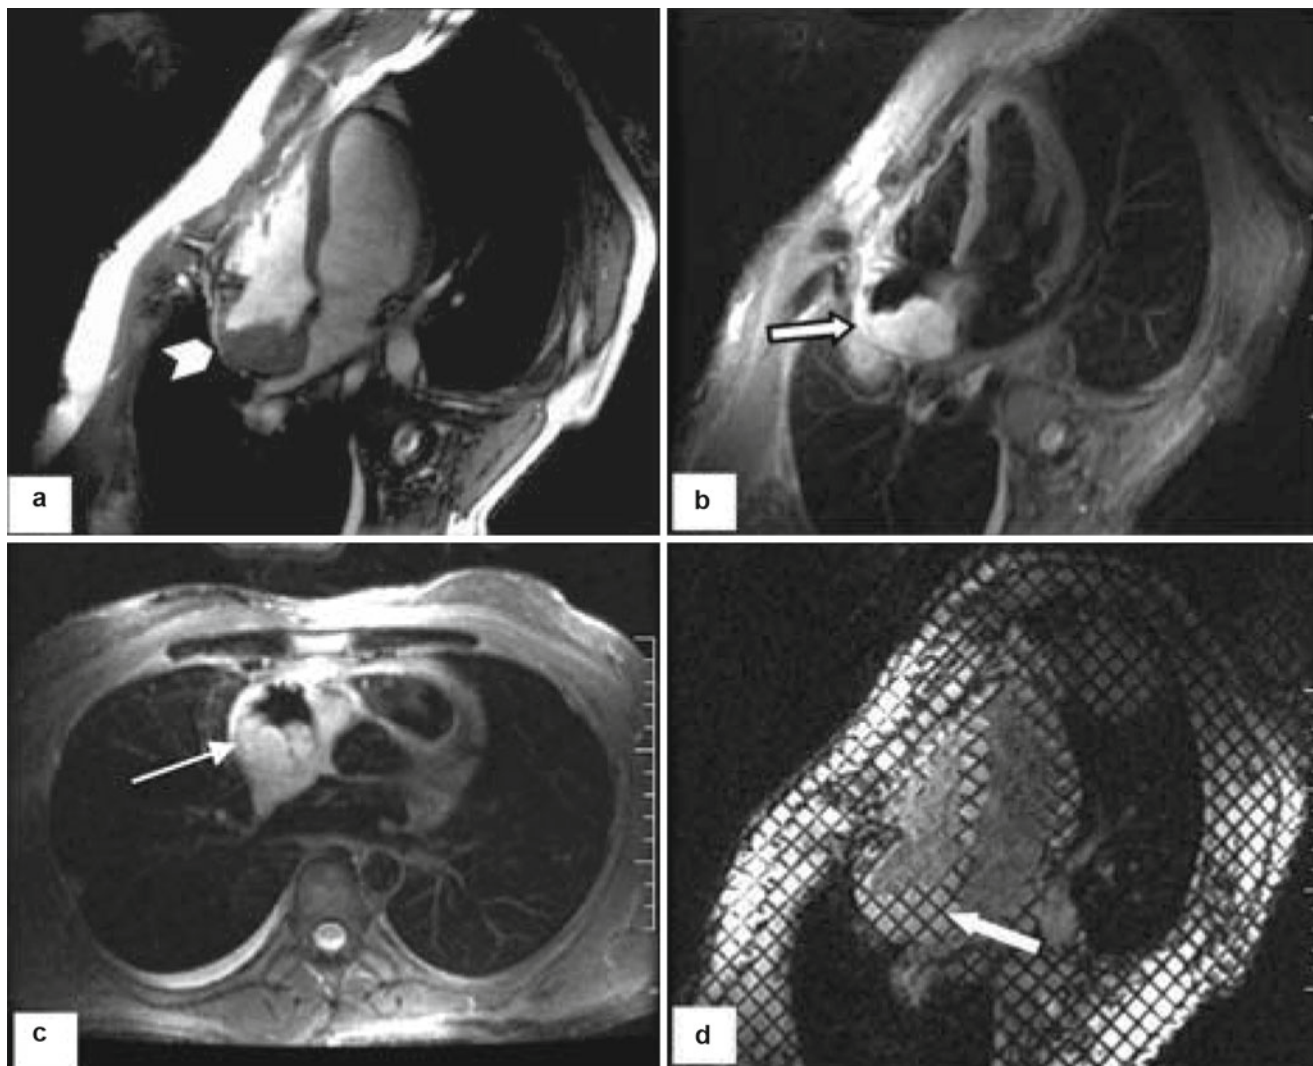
A 39-year-old with chronic cough and fullness in the upper airway for several months presented after a CT scan revealed a mediastinal mass. Mediastinoscopy/biopsy revealed a small-cell carcinoma, but the proximity to the cardiac structures was unclear. The CMR data show that the mediastinal mass has invaded through the pericardium
